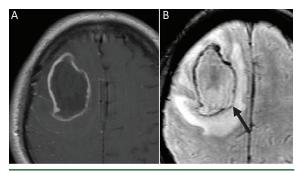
Pyogenic abscess. There is mildly lobulated rim enhancement of abscess on postcontrast T1-weighted image (A). On the axial SWAN (B), "dual-rim sign" is observed (arrow).
